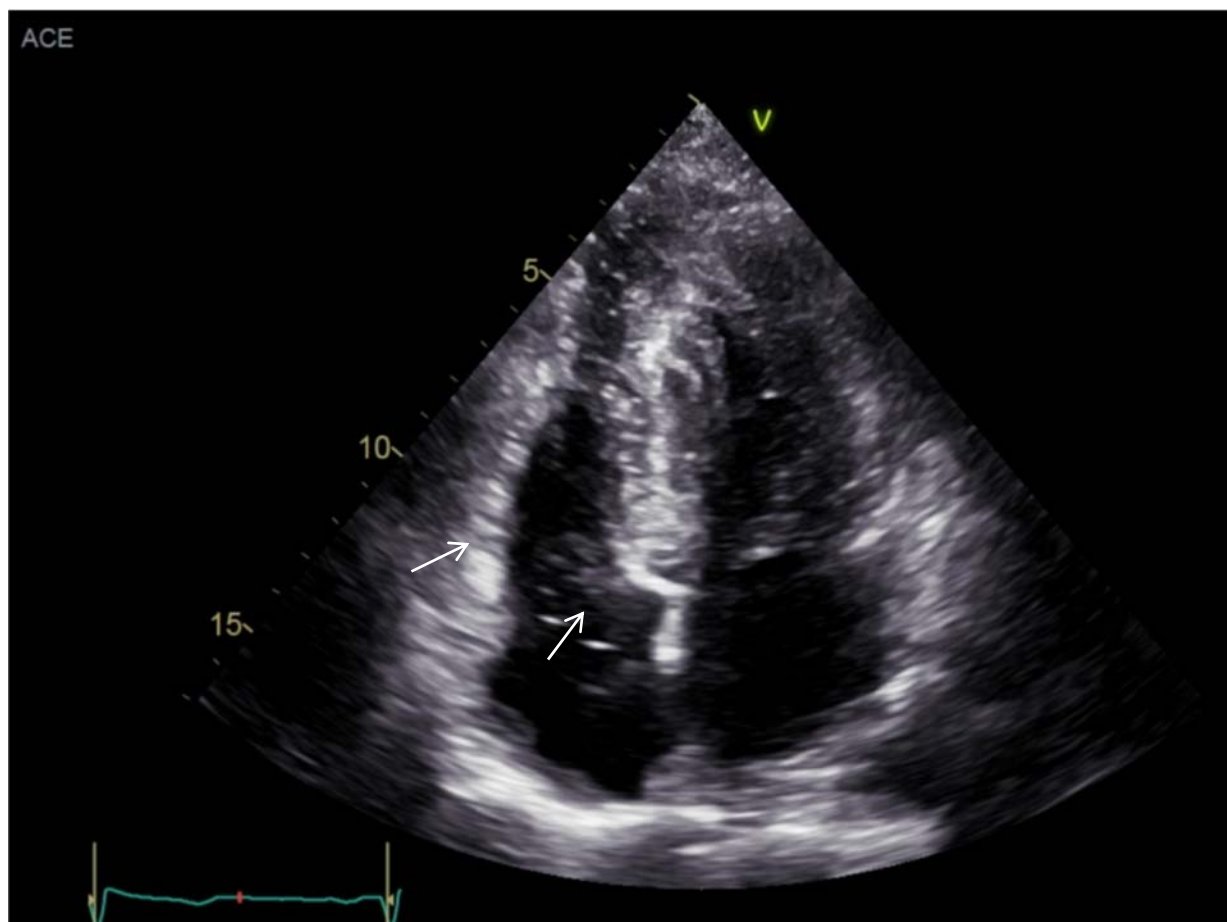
Transthoracic echocardiography image in apical 4-chamber view. In the right atrium, there is a thin-walled, oval-shaped cystic structure measuring $\sim 2.5 \times 3.0$ cm, with a smooth surface and completely anechogenic content. During diastole, the mass moves through the tricuspid valve into the right ventricle. Left ventricular apical and septal hypertrophy is seen
